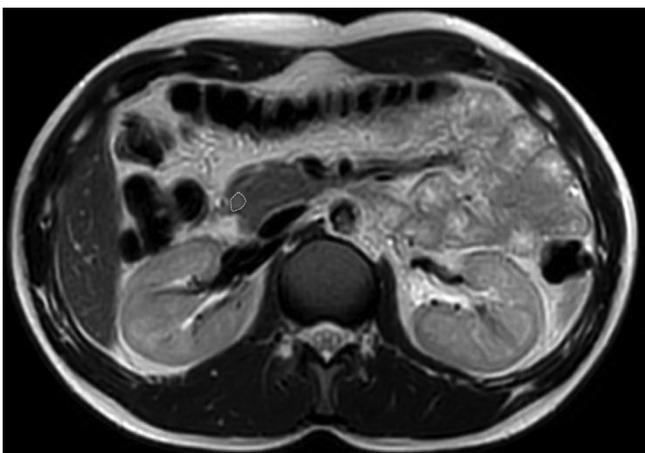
MRI after 3 years of treatment with mTOR inhibitors. Residual tumor (4×6 mm).
